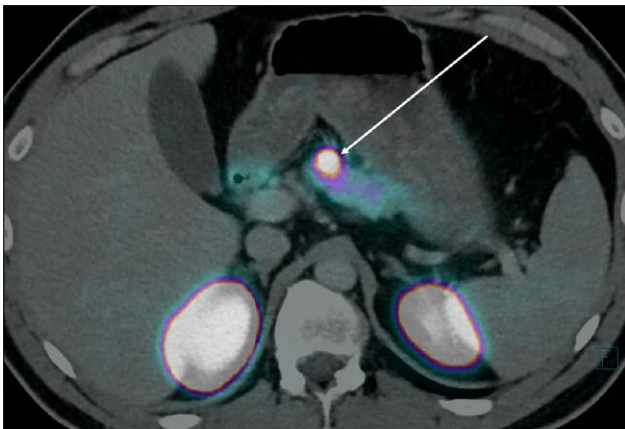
Axial ^{68}Ga -exendin-PET/CT fused image of a 45-year-old man with documented endogenous hyperinsulinemic hypoglycemia (case 1) showing a 13 \times 10-mm lesion (arrow) positive for the GLP-1 receptor and renal elimination of the tracer with uptake in the kidneys.
